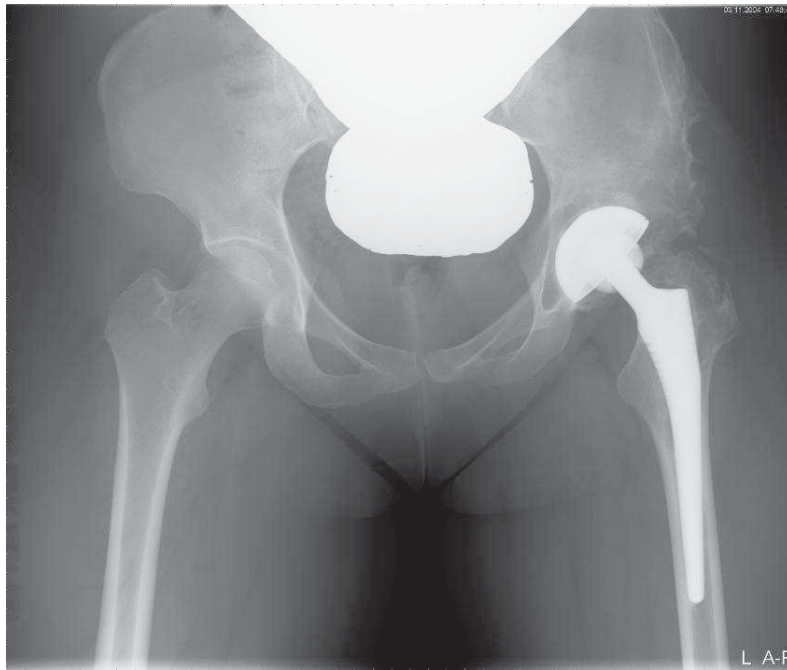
Radiograph of a 32-year-old female with a total hip replacement on the left side due to hip dysplasia.
